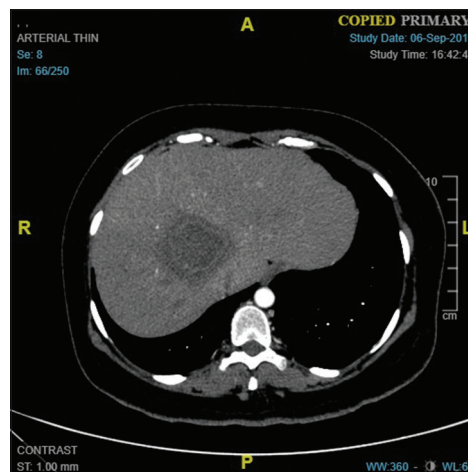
computed tomography (CT) Arterial phase shows solitary well defined roundish hypodense lesion with thin peripheral smooth enhancing wall with surrounding rim of edema measuring 47 x 41 x 39 mm in segment VIII of liver consistent with liver abscess along with mild thickening of cecum
